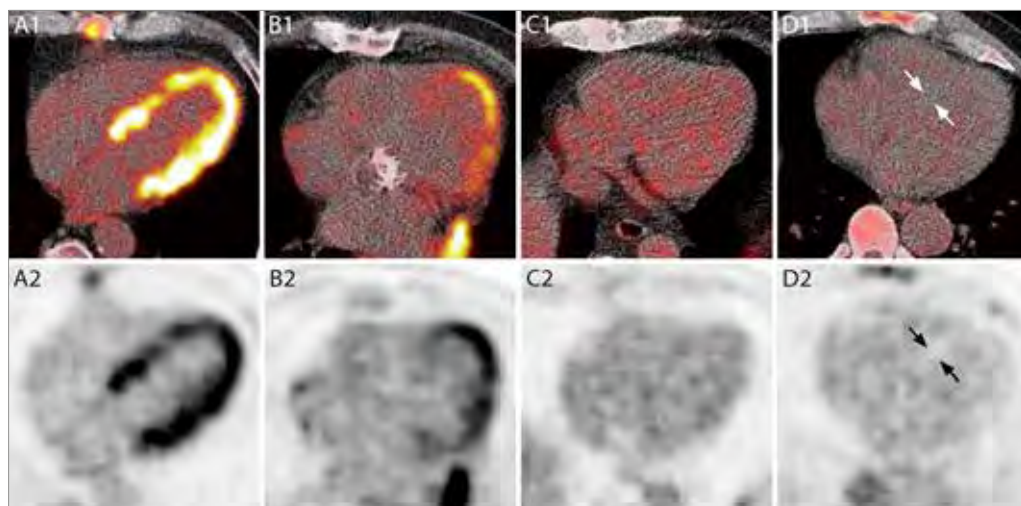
Fused positron emission/computed tomography (1) and positron emission tomography only (2) images of grades of myocardial suppression in four patients with different preparation prior to ^{18}F -fluorodeoxyglucose administration. (A) Six hour fast only: poor suppression; (B) 6-h fast and 24-h low-carb diet: fair suppression (more than blood pool, but less than liver); (C) ~12-h fast and 24-h low-carb diet: good suppression (equal to blood pool); (D) ~6-h fast, 24-h low-carb diet and 50 IU/kg of i.v. unfractionated heparin 15min prior to fluorodeoxyglucose administration: excellent suppression (less than blood pool; myocardium indicated by arrows).
